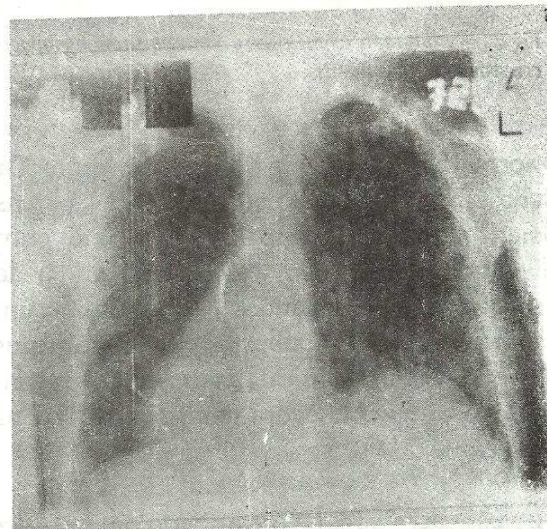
Initial chest radiograph of the patient at the age of four years (July 1990). Note the dextrocardia and situs inversus. Note the liver shadow on the left and stomach air bubble on the right, the bronchial dilatations as indicated by 'tram-line' appearance on the left side and bilateral patchy pulmonary opacities consistent with bronchiectasis and inflammation.
